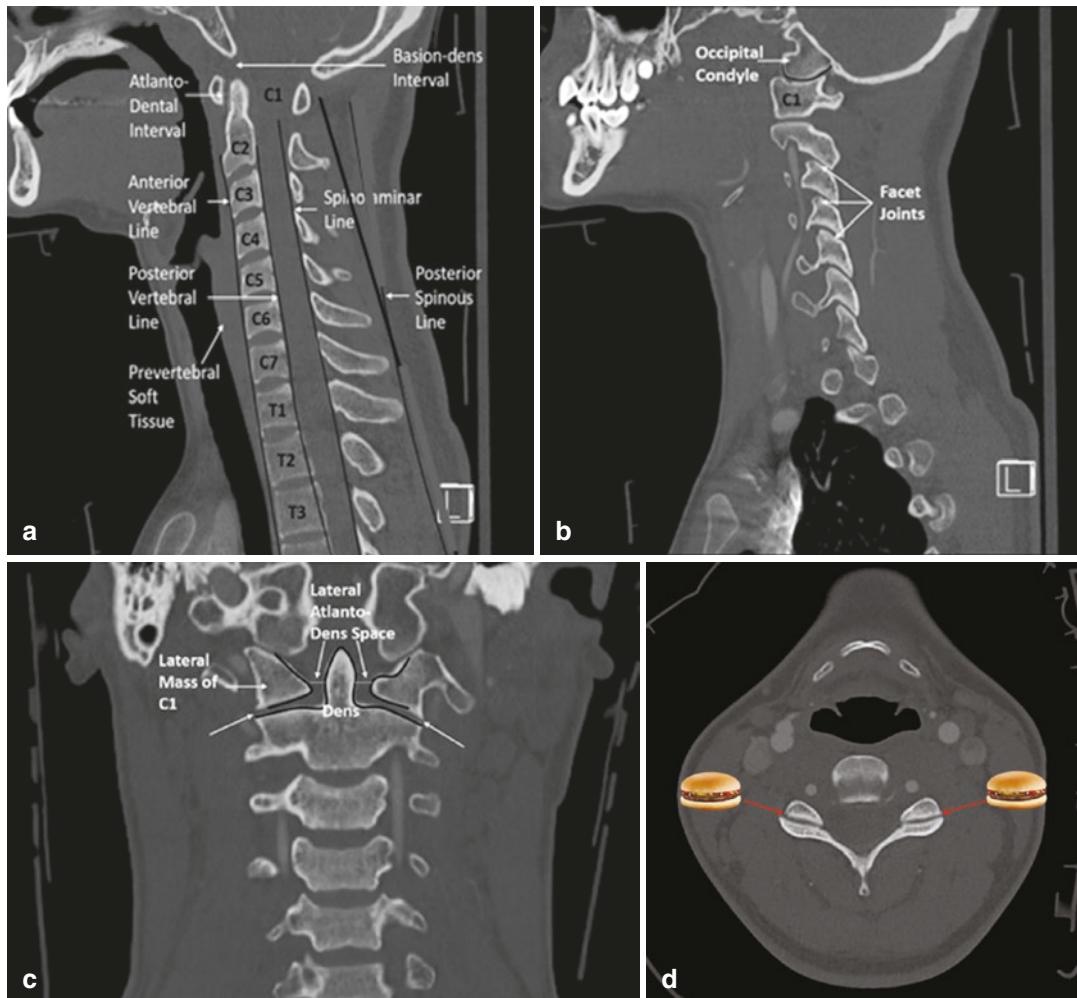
(a) Sagittal reformat cervical spine CT: The anterior vertebral, posterior vertebral, spinolaminar, and posterior spinous lines should be smooth and free of abrupt discontinuity. The basion-dens interval should be less than 9 mm, and the atlanto-dental interval should be less than 3 mm. (b) Parasagittal view on cervical spine CT: the occipital condyle should be aligned with C1, and the sum of the atlanto-occipital distance bilaterally (condylar sum) should not exceed 4 mm. Increased condylar sum may be a
